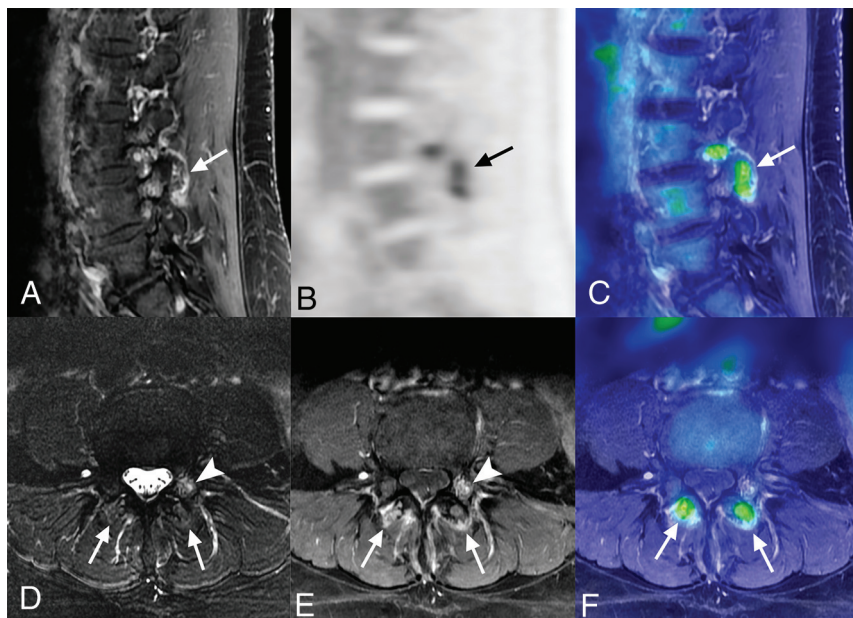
Clinical concordance of the sides of pain and imaging findings, but discordance of specific implicated facet joints. Clinically, this patient had bilateral low back pain and had been prescribed bilateral L4–L5 and L5–S1 facet joint injections. There were high-grade MR imaging scores and increased FDG activity of the bilateral L3–L4 facet joints, but not of the bilateral L4–L5 or L5–S1 facet joints (A). Sagittal fat-suppressed T1-weighted image with gadolinium demonstrates high-grade perifacet enhancement of the left L3–L4 facet joint (arrow), but not of the L4–L5 or L5–S1 facet joints (A). Sagittal FDG-PET and fused PET/MR images (B and C) also demonstrate increased L3–L4 perifacet FDG activity (arrows). Note that the FDG activity is distinguishable from areas of vascular enhancement but is not visually increased in the area of L3 pedicle enhancement (arrowhead in D and E). The perifacet signal change of the bilateral L3–L4 facet joints on axial fat-suppressed T2-weighted images is identified (arrows, D) but is more apparent on axial fat-suppressed T1-weighted images with gadolinium (arrows, E). An axial fused PET/MR image also demonstrates increased perifacet FDG activity of the bilateral L3–L4 facet joints (arrows, F).
